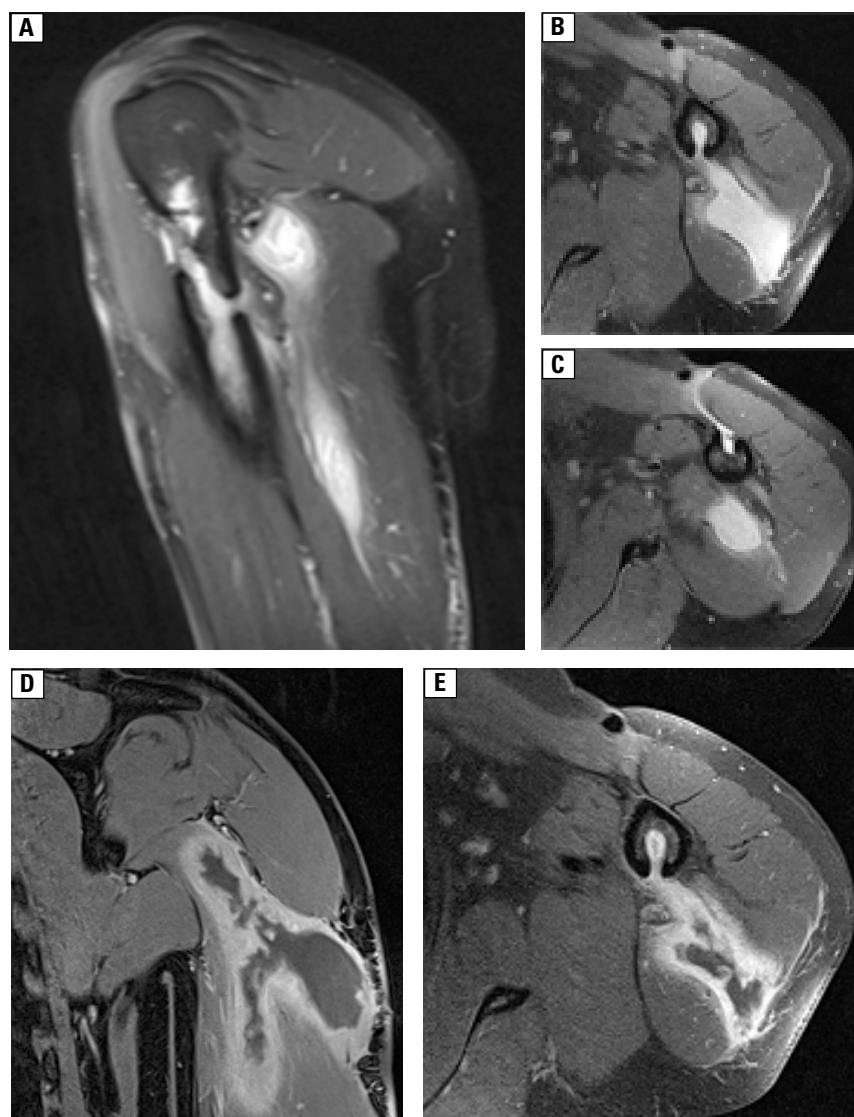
Initial MRI examination of the brachium. A–C — sagittal and axial PD-weighted images with fat saturation; D, E — coronal and axial T1-weighted contrast-enhanced images
